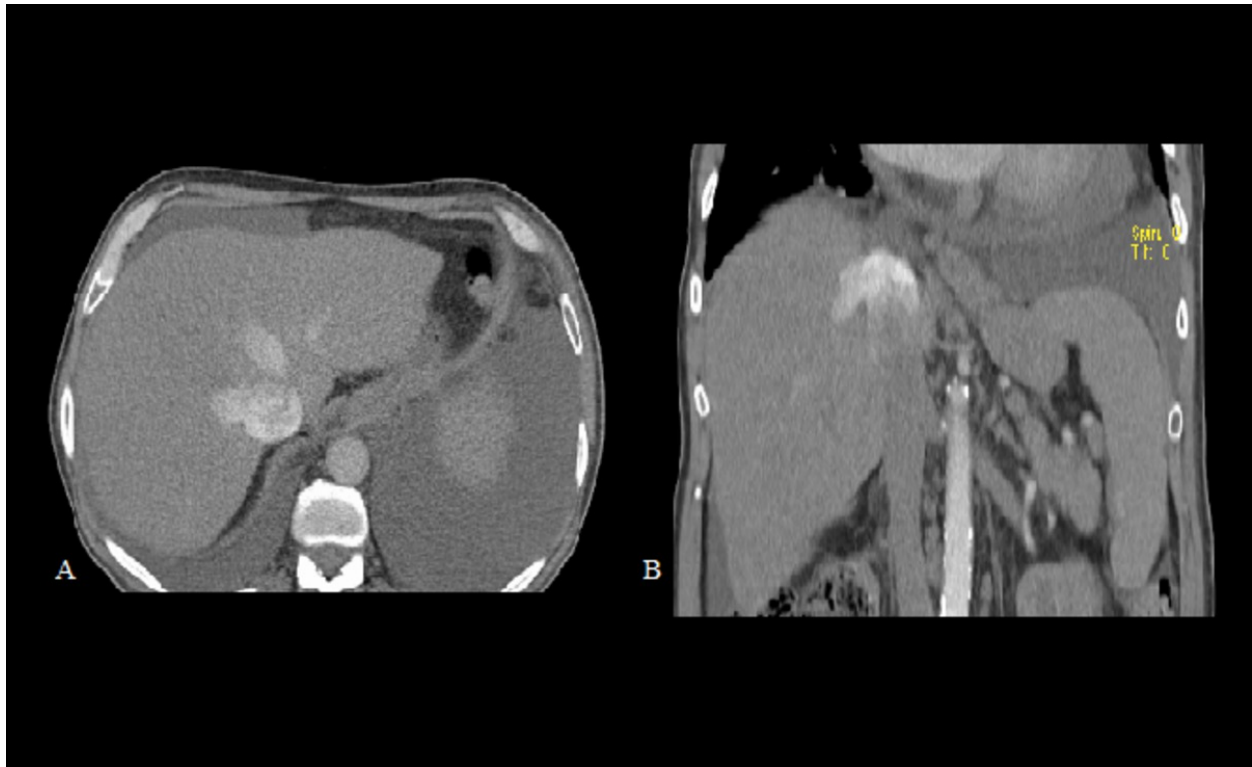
Retrograde contrast enhancement of the IVC: Axial and coronal enhanced computed tomography reformations (arterial phase) reveal dense undiluted contrast material in the IVC and hepatic veins.
